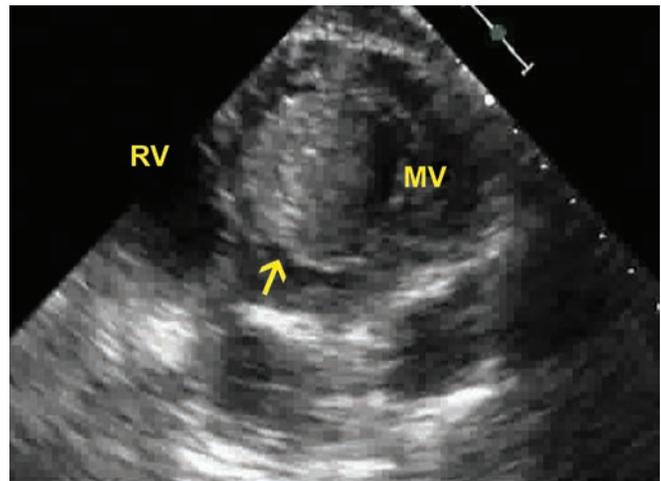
Transthoracic echocardiography. Parasternal short axis at the level of the mitral valve. (RV: Right ventricle; MV: Mitral valve). Arrow points to the myxoma protruding through MV.
